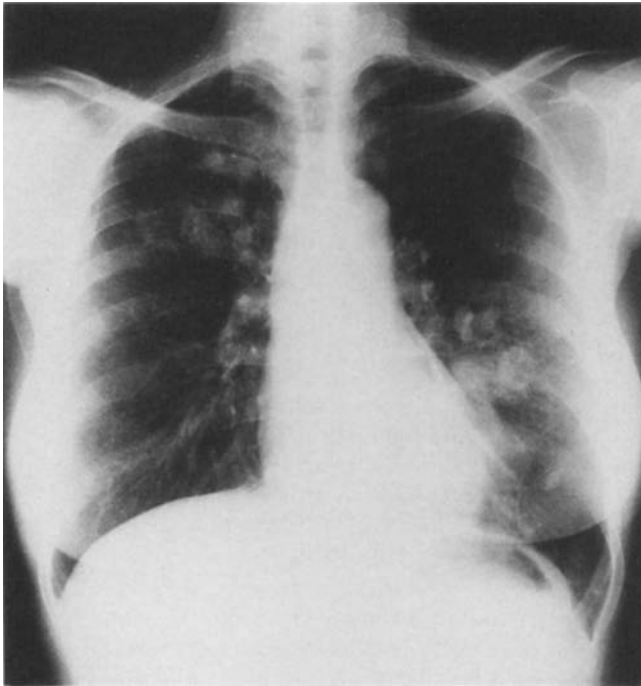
Chest roentgenogram on admission disclosing an infiltrate and nodular shadows in the right upper lobe and left lingular lobe.
